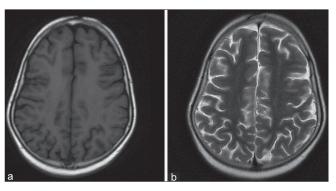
T1- (a) and T2-weighted images (b) at presentation are unremarkable
